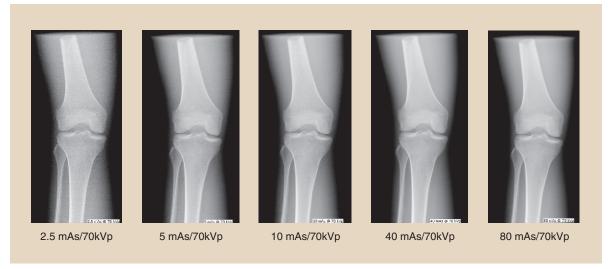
Computed radiography (CR) images obtained through the same radiographic technique used in Figure 15-17. (Courtesy Betsy Shields, Presbyterian Hospital, Charlotte, North Carolina.)
